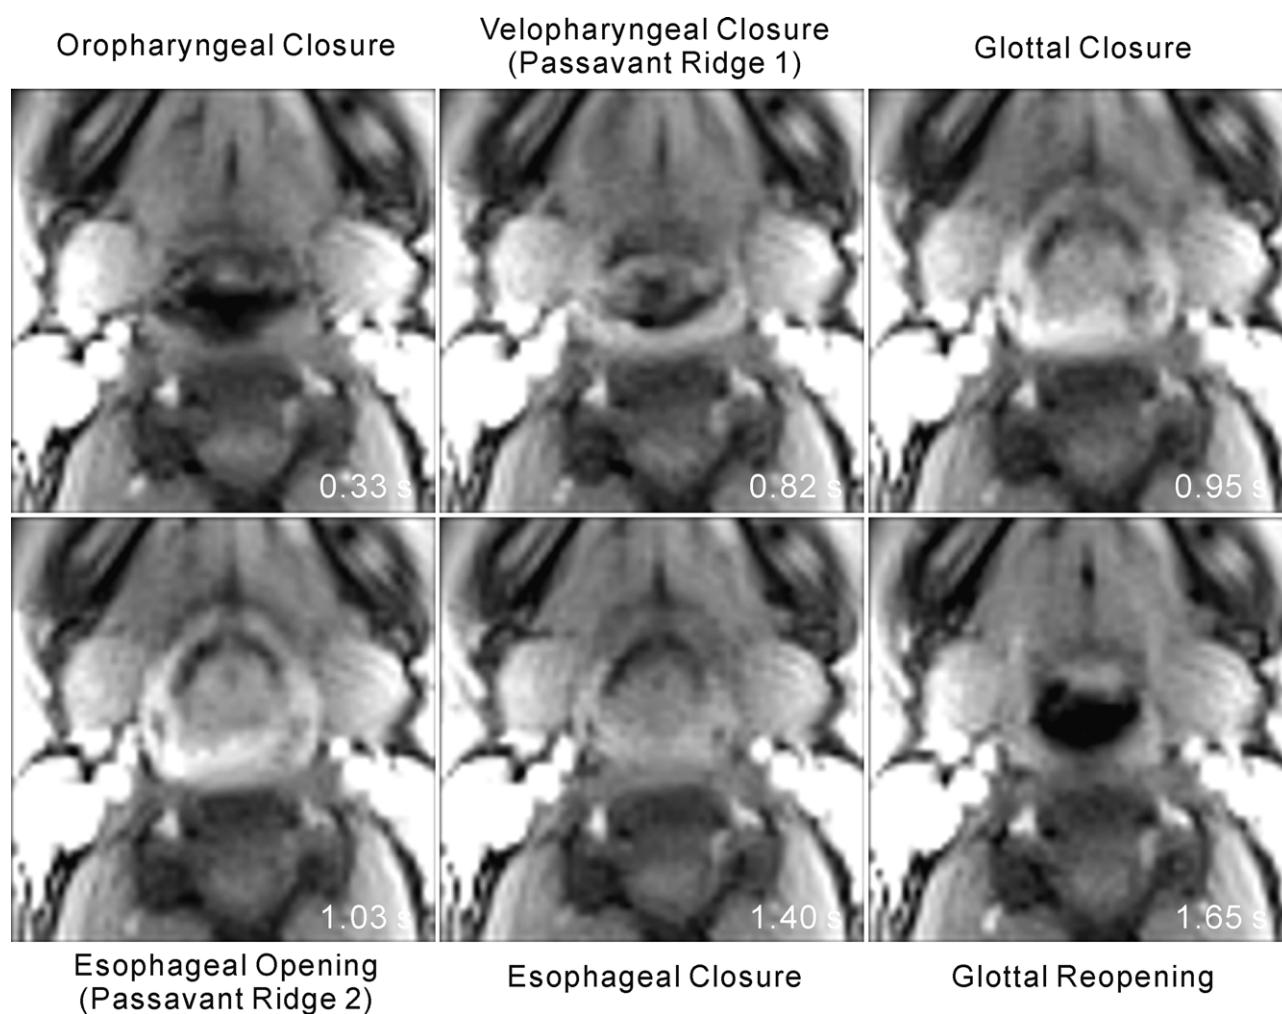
Real-time MRI of normal swallowing in an axial plane (same subject and parameters as in Fig. 2). The images represent distinct swallowing events (relative timings as in Fig. 2) from a corresponding movie of a single swallow at 24.3 fps (see Supporting Movie 3).
